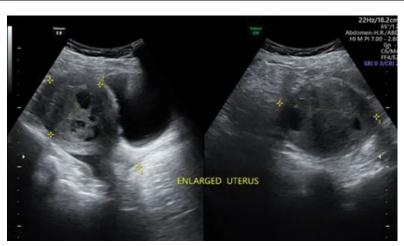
Ultrasound showing the heterogeneous lesion in uterus.
